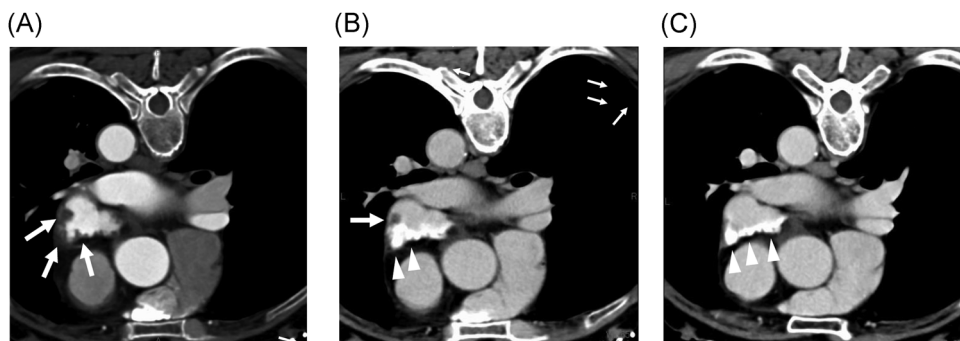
Change in contrast defects (CDs) by altered oral anticoagulant therapy. Contrast computed tomography (CT) in the prone position was performed in the early (A) and late phases (B). Both images showed CDs. We changed the oral anticoagulant from edoxaban to rivaroxaban, and 3 months later, subsequent CT showed the disappearance of the CD, and residual contrast was observed along the margin of the left atrial appendage under the same CT conditions (C). Arrows show CDs, and arrowheads show residual contrast
